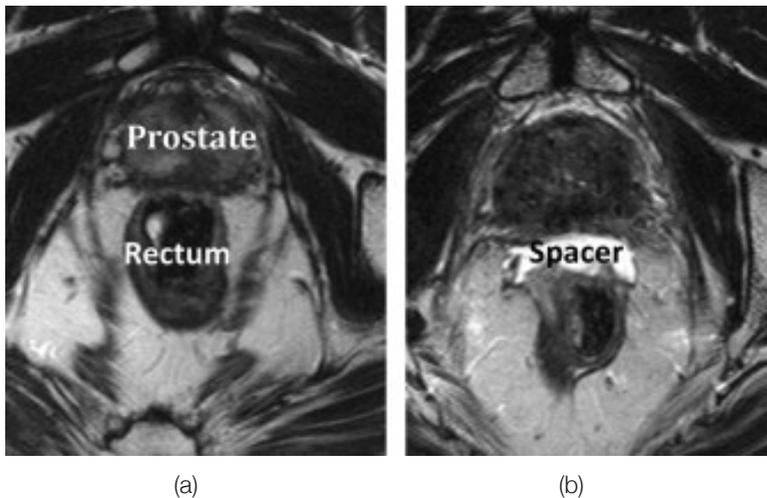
Axial T2 magnetic resonance images of a patient with a spacer before injection (a) and after injection (b).
